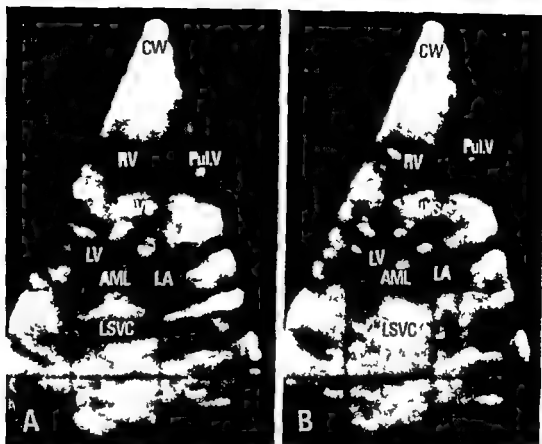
Cross sectional echocardiograms in the patients with PLSVC before (A) and after (B) dye injection. These pictures were recorded along the cross section of the sagittal plane of the chest. An echo free space is recognized posterior to the two left sided heart chambers before dye injection (A) but the positive contrast echo appears in its echo free space after injection of the indocyanine green from the left medial cubital vein (B). Abbreviations: CW = chest wall, Pul V = pulmonary valve, RV = right ventricle, IVS = interventricular septum, LA = left atrium, AML = anterior mitral leaflet, LV = left ventricle, LSVC = left superior vena cava.
